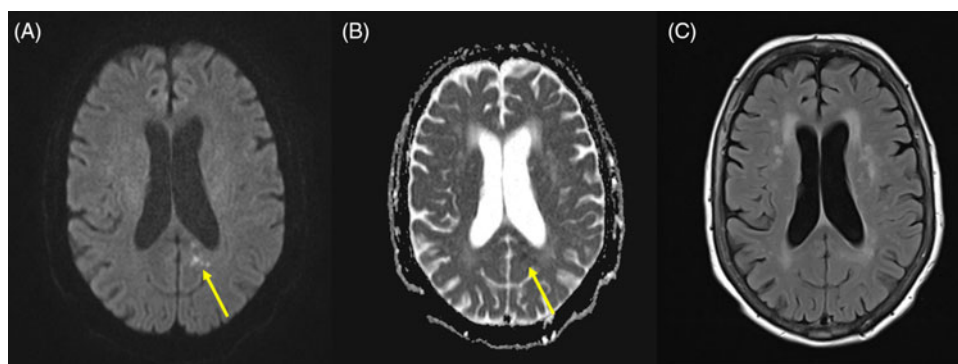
Axial MRI, DWI (A) and corresponding ADC (B) demonstrate restricted diffusion in the left splenium and retrosplenium (arrow) consistent with acute infarction. T2 FLAIR (C) hyperintensities in diffuse periventricular and subcortical white matter consistent with chronic ischemic changes. DWI = diffusion weighted imaging, ADC = apparent diffusion coefficient, FLAIR = fluid attenuated inversion recovery.
